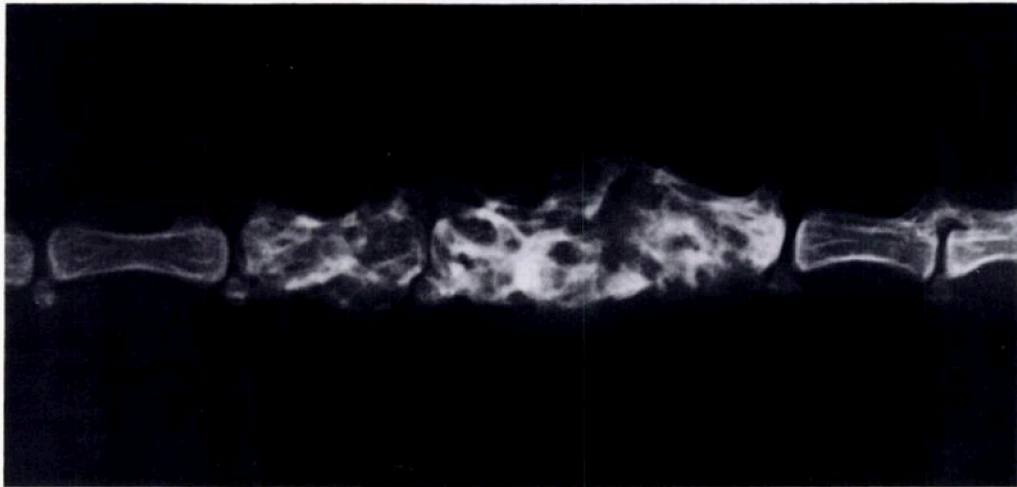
A lateral radiograph of the tail of a brush-tailed bettong showing extensive bone destruction and remodelling of three coccygeal vertebrae.
